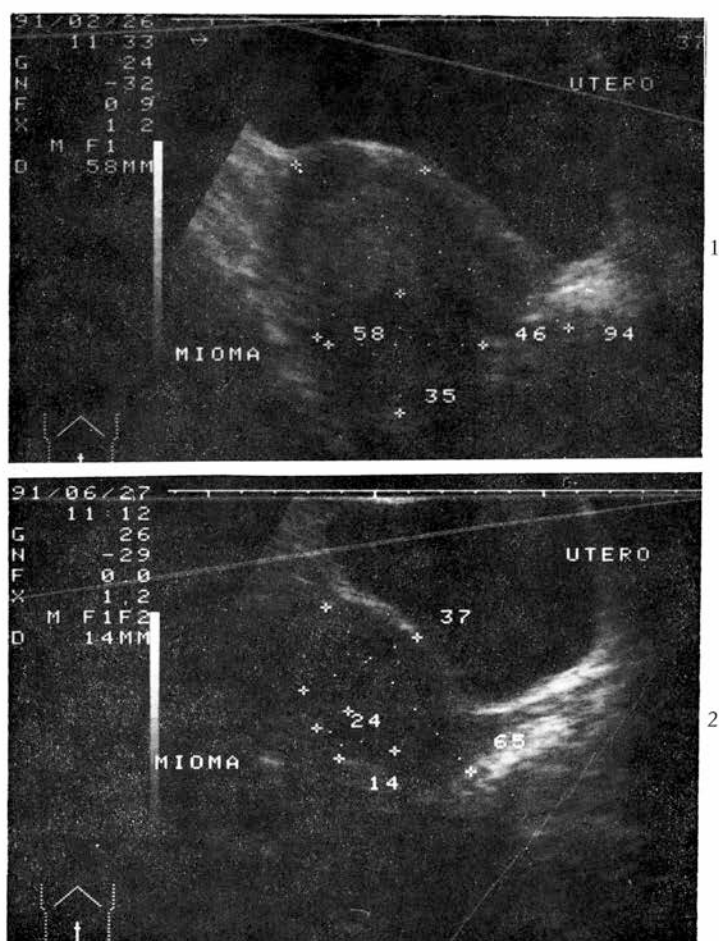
Shrinkage in uterine volume in a 36-year-old patient before and after three months of medical treatment (confirmed by ultrasonographic examination).
